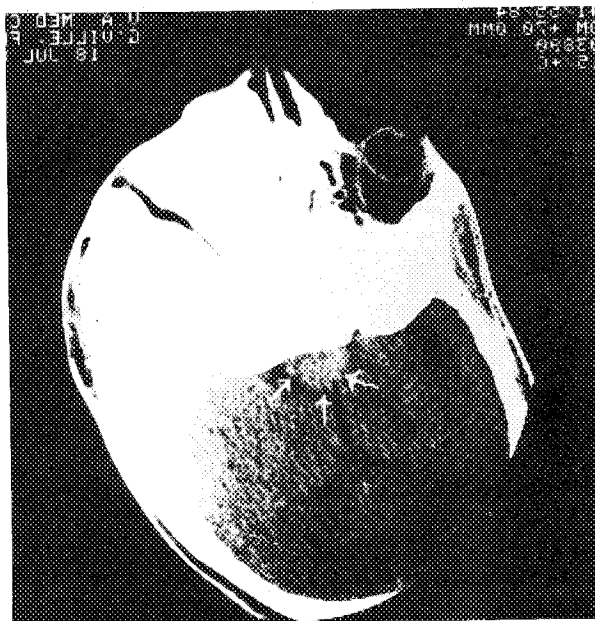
Coronal CT scan demonstrating mass lesion in the sella region.
